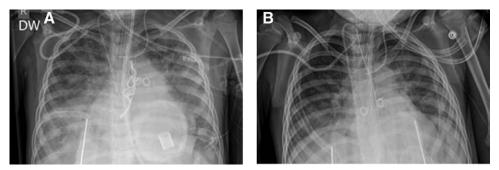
Intraoperative photo showing the heart is rotated to the right with 9 mm Berlin inflow cannula being sewn into left atrial appendage with 5-0 prolene sutures. A. Chest X-ray showing pulmonary edema with Berlin Heart 9 mm apical LV cannulation. B. Chest X-ray showing improved pulmonary edema with Berlin Heart 9 mm LA cannulation. LA cannulation, left atrial cannulation; LV, left ventricle.
